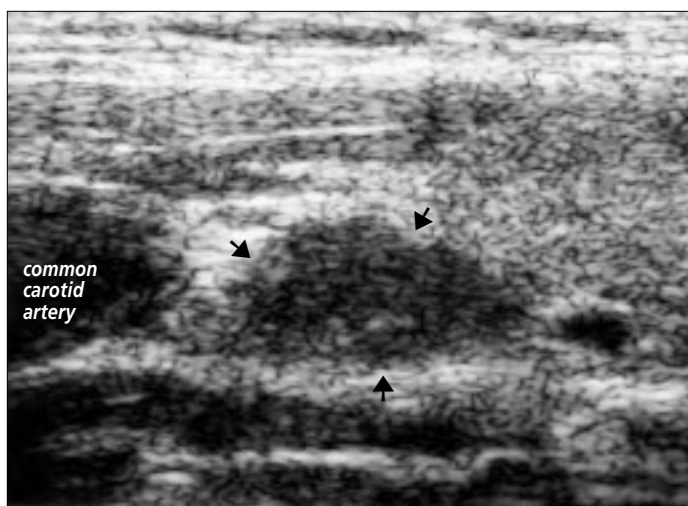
Ultrasound image demonstrates a left superior parathyroid mass (arrows), 12 mm in maximum dimension.
